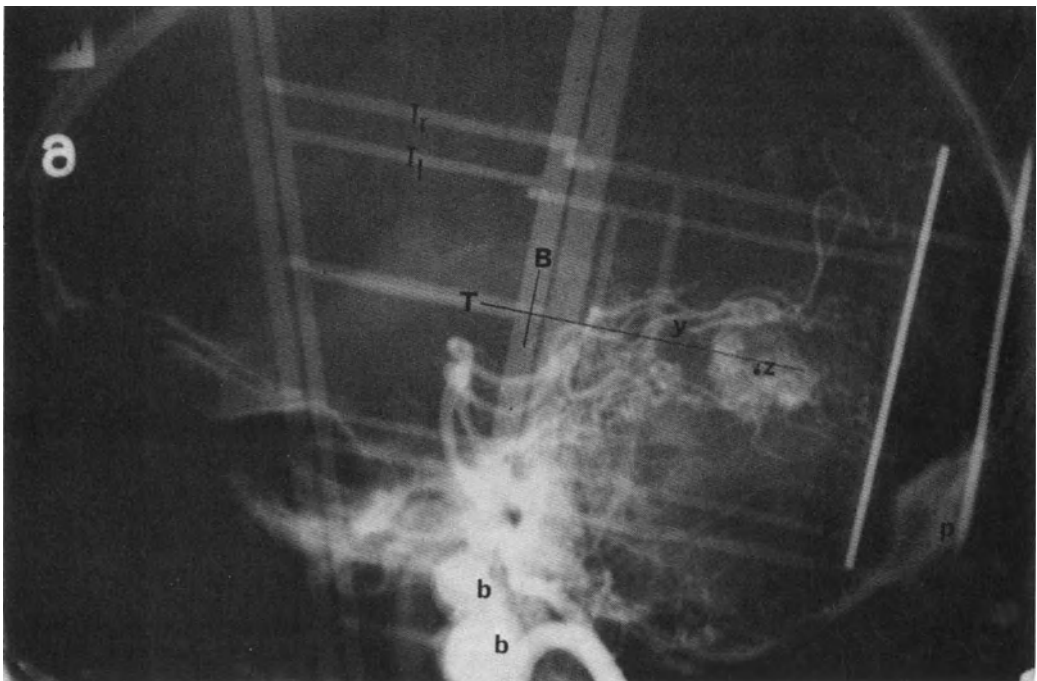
Lateral angiogram showing the binaural plane (B) and the plane of the second transverse arms (T), to which the vascular target (dot) is related with Y and Z coordinates. The x-ray magnification rate for any laterality level can be measured from the magnifications of the left (T_l) and the right (T_r) transverse arms.
